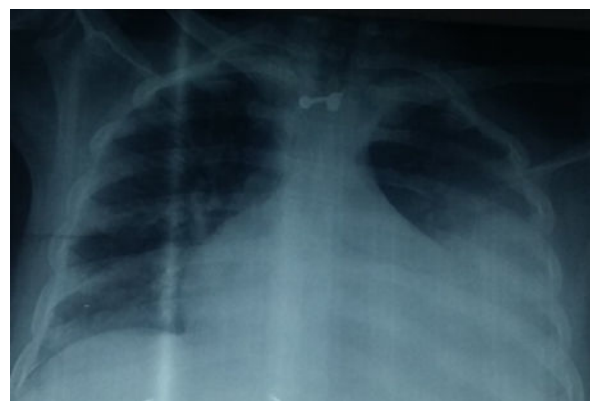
Chest radiograph showing a bilateral basal pulmonary opacity.
